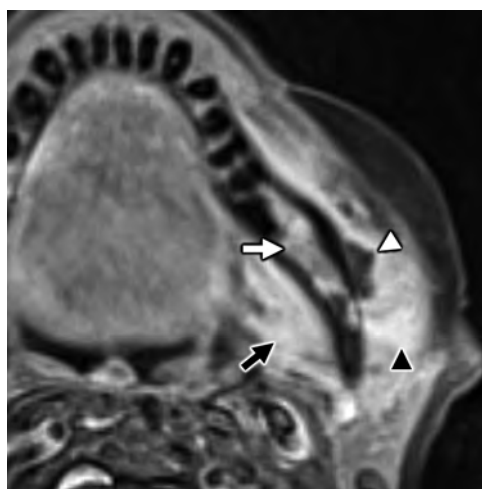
A 35-year-old man with secondary otalgia caused by perineural tumor spread from parotid adenoid cystic carcinoma. Axial T1-weighted postcontrast fat-saturated MR imaging shows cordlike enhancement (*white arrow*) along the course of the *auriculotemporal nerve*, which serves as an extracranial bridge linking the intraparotid *facial nerve* to CN V3 (*black arrow*) in the infrazygomatic masticator space. Note hyperenhancement along the descending mastoid segment of CN VII (*white arrowhead*) from additional perineural tumor spread. In this case, referred otalgia may occur along the *auriculotemporal nerve*, CN V3, and/or CN VII.
